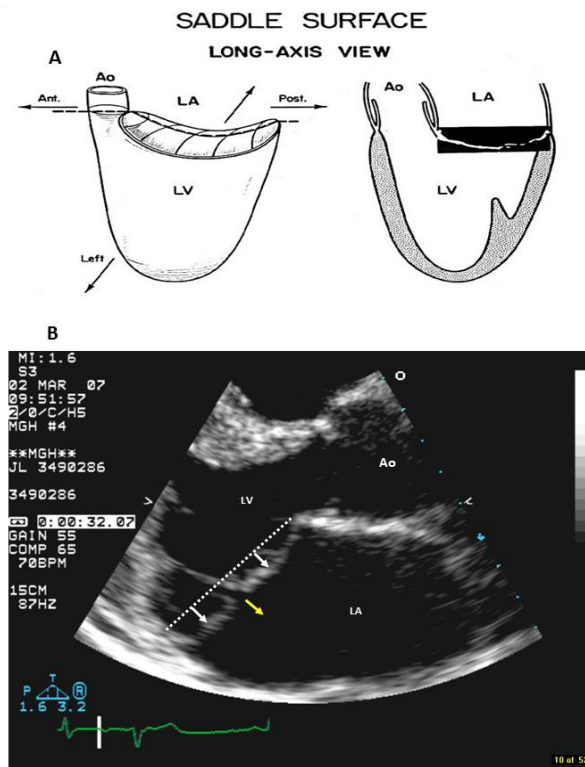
A. Mitral valve prolapse (MVP) is defined by the abnormal relationship of the mitral leaflets to their surrounding structures; cardiac ultrasound is well suited for MVP phenotyping; B. Parasternal long axis view of a human with MVP. The leaflets are above the annular line (dotted line) during systole (white arrows). Gap between the leaflets generates potential for regurgitation (yellow arrow). Adapted from [6]
